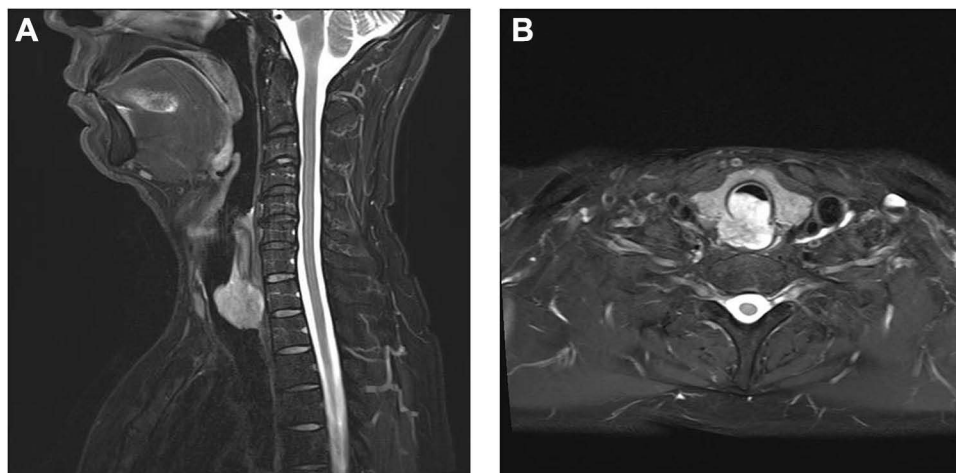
T2 weighted magnetic resonance imaging of upper tracheal tumor. (A) Sagittal view and (B) transverse view.
